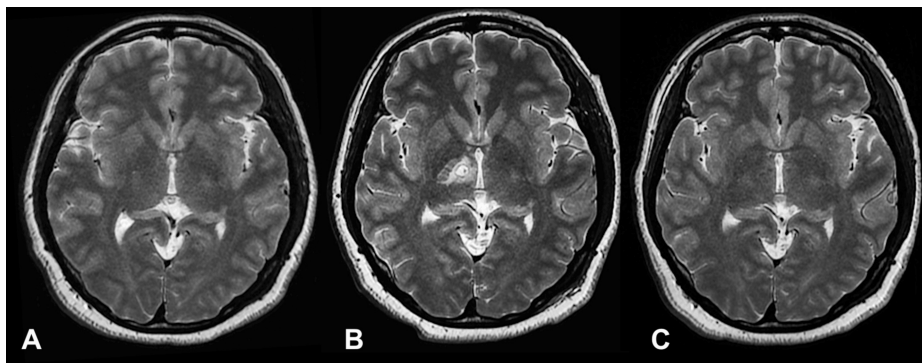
MR-guided focused ultrasound ablation of the right pallidothalamic tract (tractography-guided targeting).
